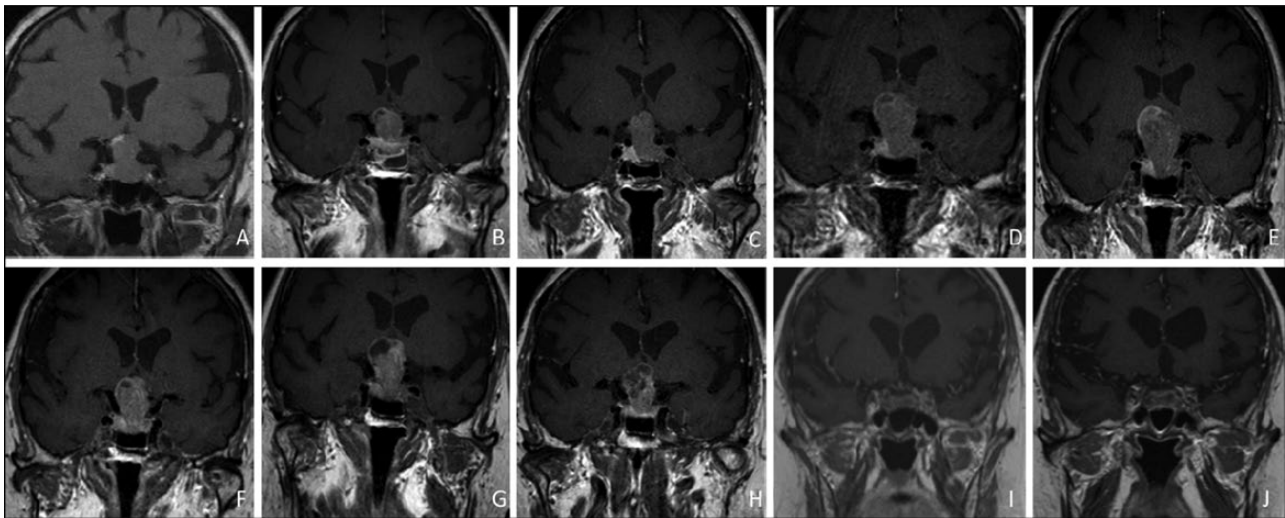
Radiological modifications of the PA on coronal T1 weighted MRI images. (A) First MRI evaluation showing a sellar lesion with suprasellar extension and optical chiasm involvement. (B) Macroresidual of tumor after surgery. (C) Regrowth of tumor mass 5 months after surgery. (D) Enlargement of tumor mass after 8 months of cabergoline treatment. (E) Further tumor enlargement despite 5 months of therapy with pasireotide. (F) Apparent minimal reduction of tumor mass one month after finishing external radiotherapy (total dose 54 Gy). (G) Volumetric increase >50% of the macroadenoma 10 months after external radiotherapy, with further compression of the anterior wall of third ventricle and of the hypothalamus. (H) Initial shrinkage of tumor mass after 3 cycles of TMZ. (I) Remarkable tumor reduction with cystic degeneration after 39 cycles of TMZ. (J) Sustained response without modifications of the minimal residual lesion 4 months after TMZ withdrawn.
